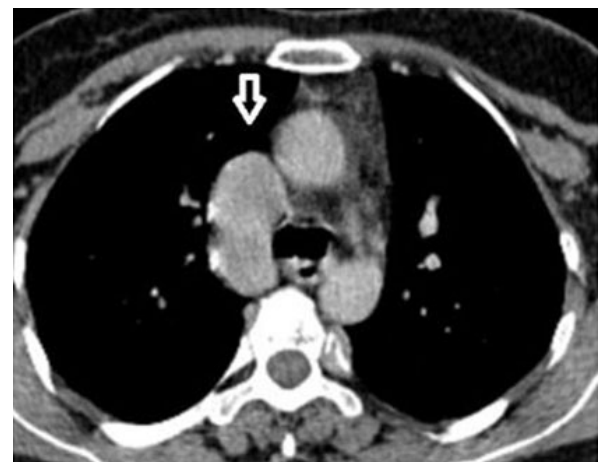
Enhanced abdomino-pelvic CT scan at the portal phase showing enlarged azygos vein substituting for the inferior vena cava (arrow).
